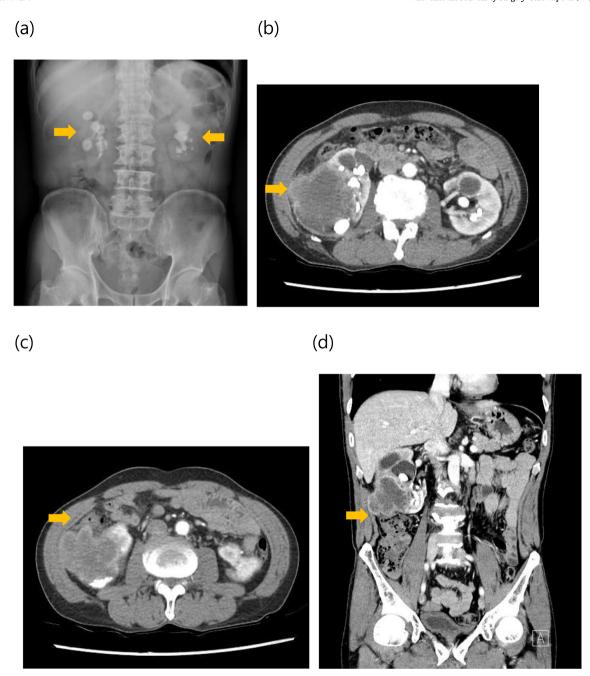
(a) X-ray of the kidneys, ureters, and bladder showed multiple renal stones and staghorn stones in both kidneys. Contrast-enhanced computer tomography showed a large mass in the right kidney. The mass invading into the perirenal fat tissue (b) and ascending colon (c and d).
